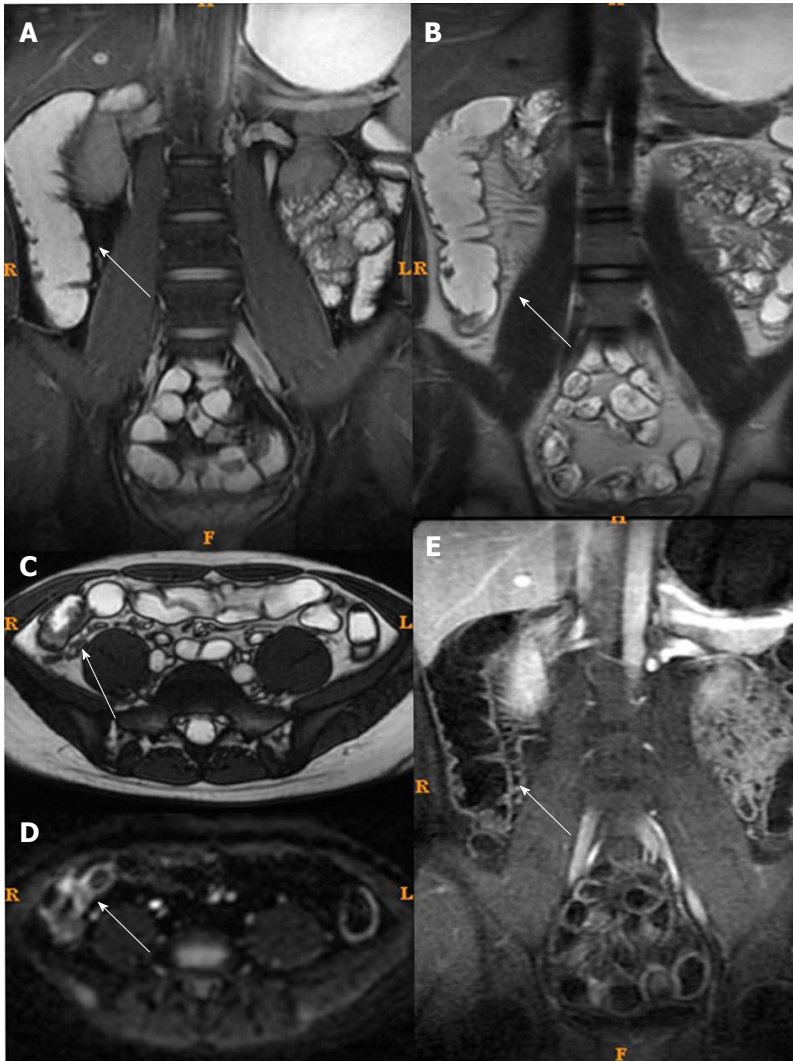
Magnetic resonance imaging of a typical case of active Crohn's disease after treatment (same patient as in Figure 3). The patient was in remission (inactive Crohn's disease) after treatment. A: Fast imaging employing steady-state acquisition showed decreased intestinal wall thickening and no submucosal edema; B and C: T2WI showed decreased intestinal wall thickening and no submucosal edema; D: Diffusion weight imaging showed less high intensity; E: Enhancement showed less enhancement.
